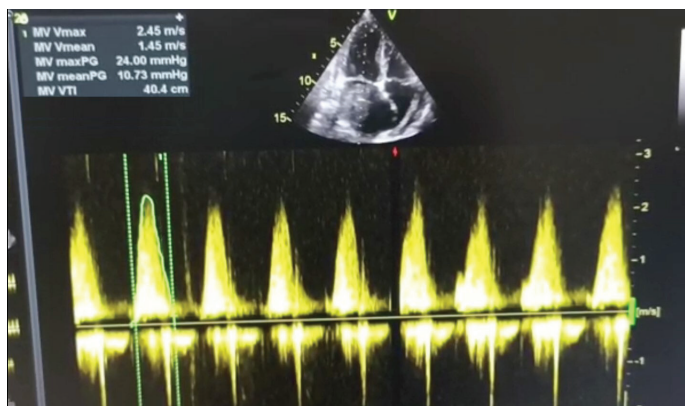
Doppler echocardiography shows severe mitral stenosis.
